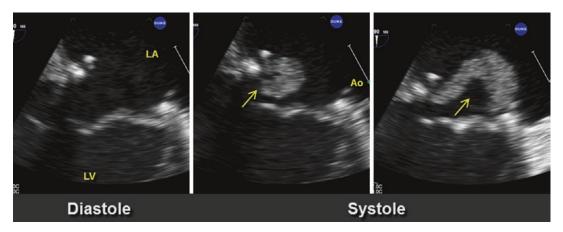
Transesophageal two-dimensional zoom views through a patient who previously underwent a mitral valve repair and placement of a mitral ring and 2 years later presents with fever and positive blood cultures for *S. aureus*. Left panel shows diastole with no evidence of a vegetation as it was down into the left ventricle. The
